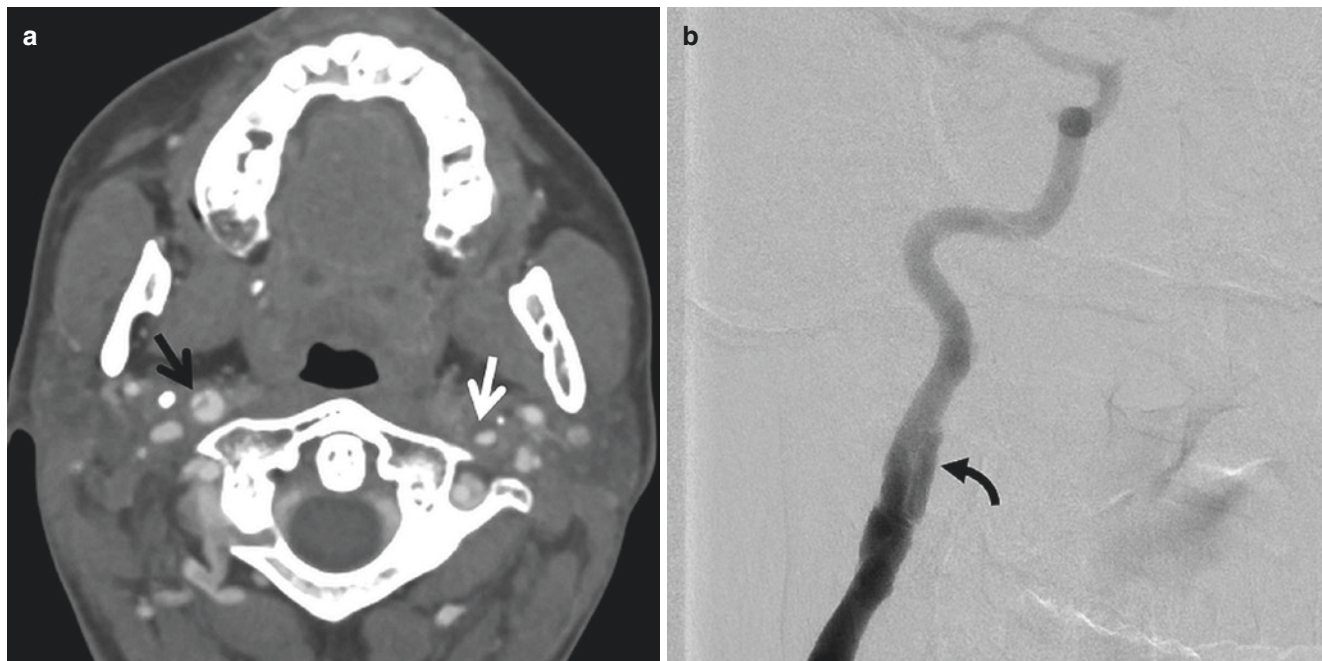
Grade II ICA injury with intimal flap. (a) Axial CTA of a patient with high-speed motor vehicle collision demonstrates mild dilation of right ICA with an intimal flap at the level of C1 (black arrow).
